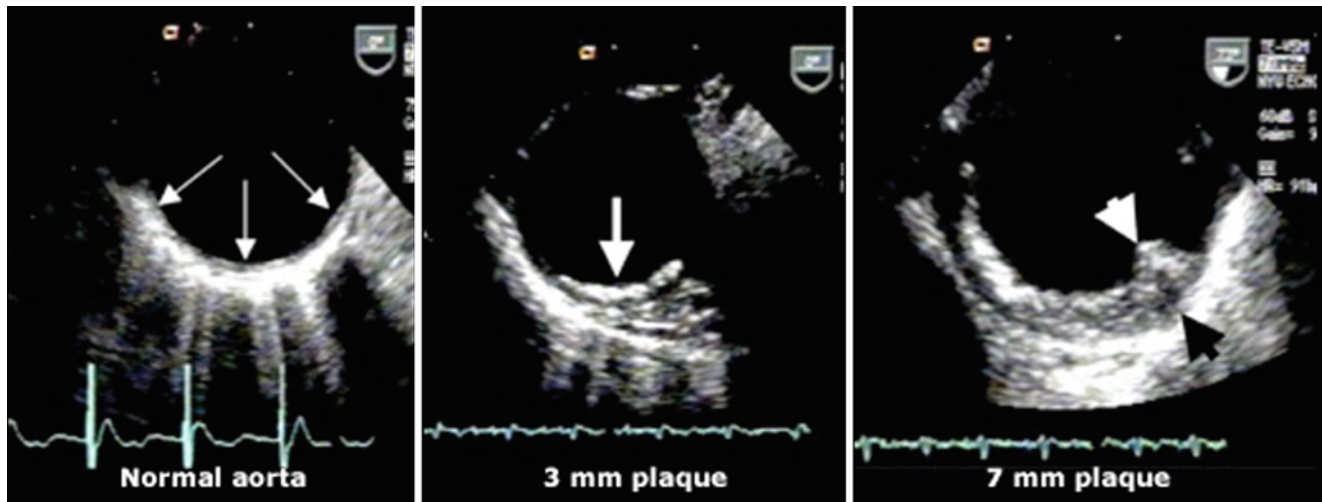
Transesophageal echocardiograms of the thoracic aorta: *Left*: normal; *middle*: moderate (3 mm) plaque; and *right*: severe (7 mm) plaque (Reprinted with Permission Tunick [89])
